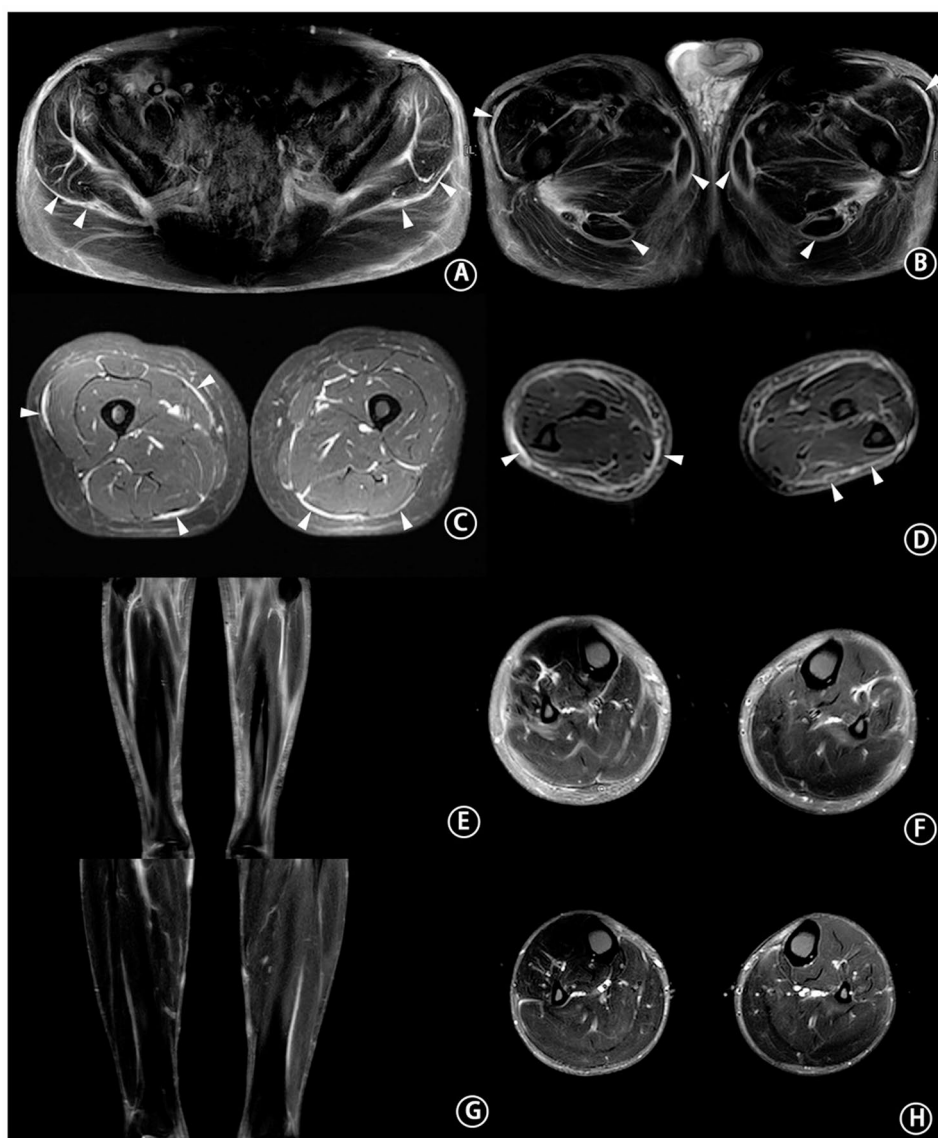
Representative MRI on hyperintense short T1 inversion recovery (STIR) sequence. (A, B) Apparent edema of the fascial and the adjacent subcutaneous tissue in P13 at the pelvic level. (C) Fascial edema without involvement of adjacent subcutis in P16 at the thigh level. (D) Fascia edema of bilateral forearm in P5. The fascia beneath the subcutis was usually preferentially involved rather than that lying between the muscle bundles (A–D, arrowheads). (E–F) Apparent edema and inflammation of fascia and the adjacent subcutaneous tissue in P10 before treatment. (G–H) The edema and inflammation of P10 were significantly alleviated after treatment with prednisone and methotrexate
